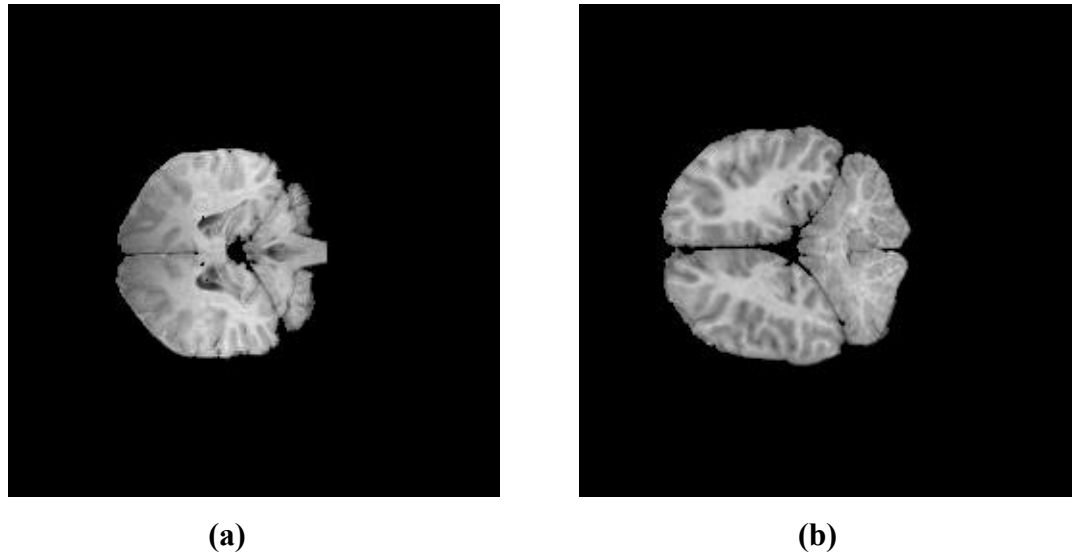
Normal MRI slices from IBSR (10Normals_T1) dataset, (a) Slice 22 of patient Normal_4, and (b) Slice 16 of patient Normal_15
